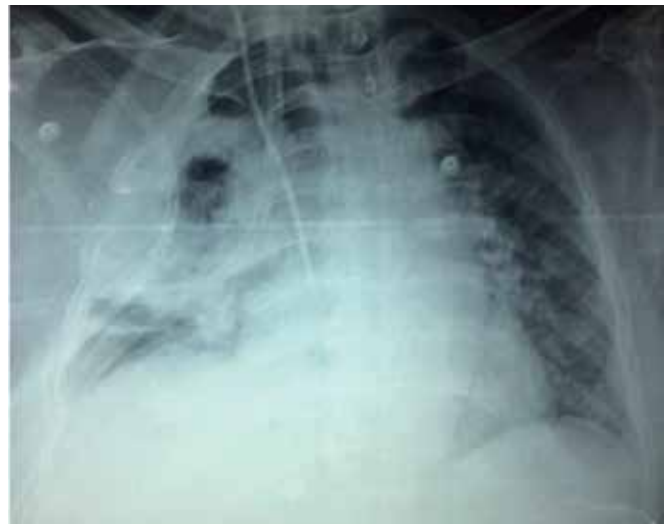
Bedside chest radiograph (postero-anterior view) revealed right-sided thick-walled cavitation and ground-glass opacity in both the lung fields.
